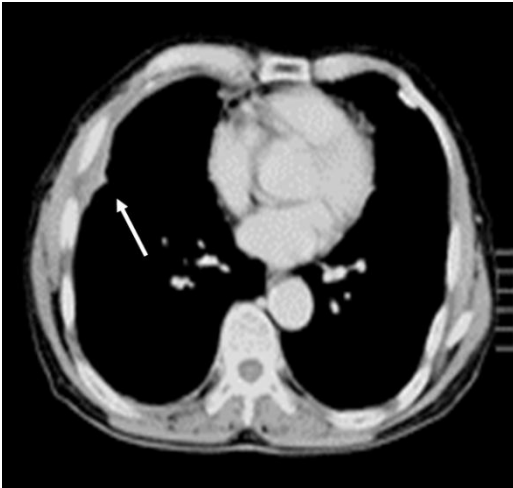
Chest CT of the pleural mesothelioma case only indicating irregular protrusion to a portion of the right pleura. On the other hand, left pleura shows typical pleural plaque.
